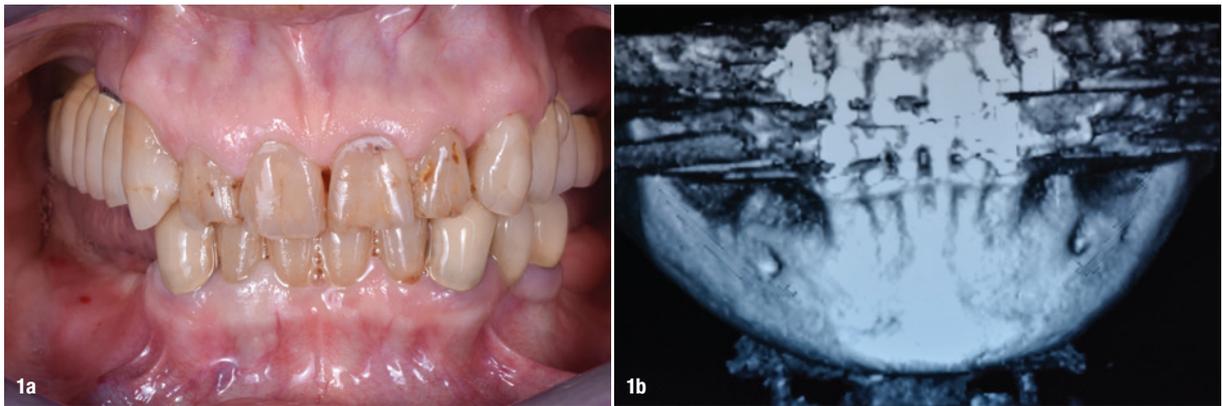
Initial situation. Figs. 1b & c: Initial CBCT scan.
